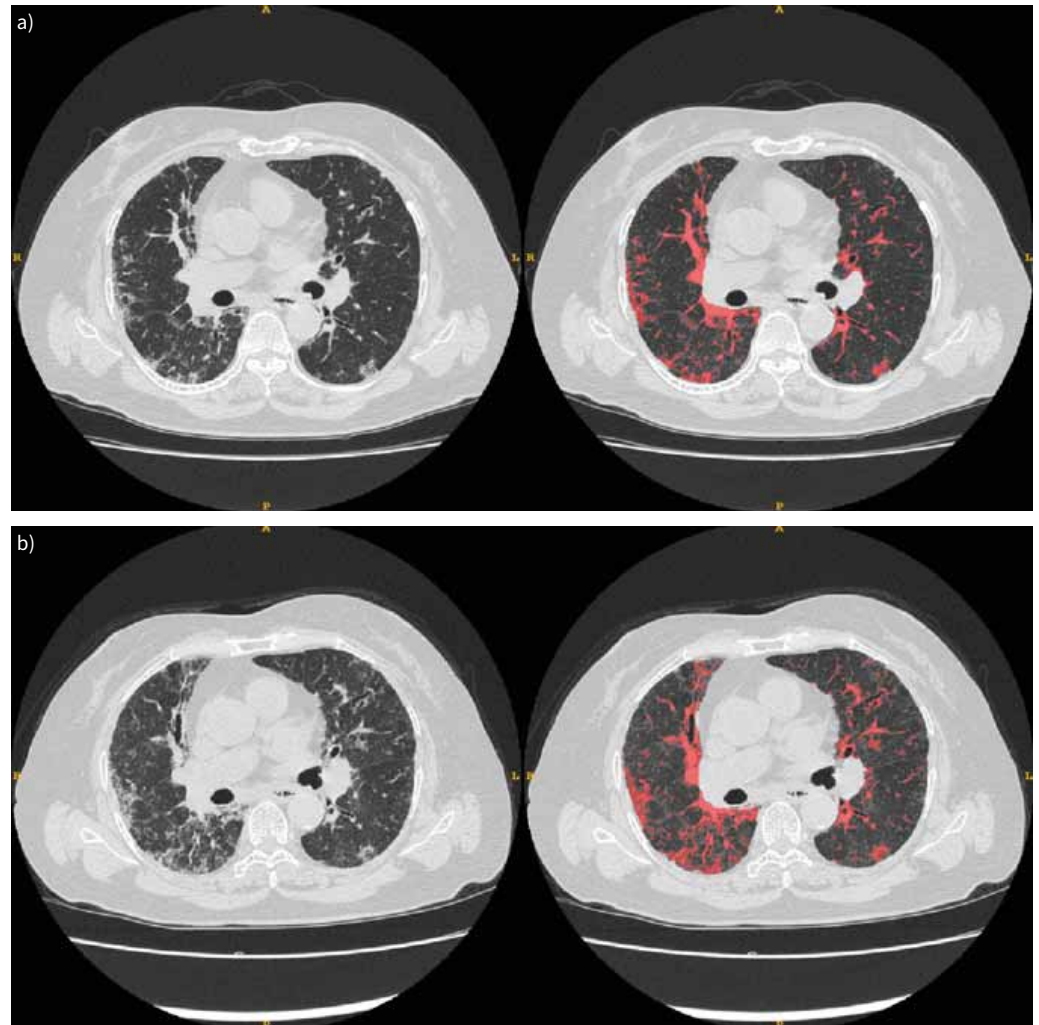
Example of a patient from the Open Source Imaging Consortium with a) baseline and b) follow-up computed tomography scans, 50 weeks apart. The left-hand side of each panel shows the original high-resolution computed tomography scan and the right-hand side demonstrates the e-Lung segmented reticulovascular structures. The weighted reticulovascular score for a) the baseline scan is 20.1% and b) the follow-up scan is 27.2%.
